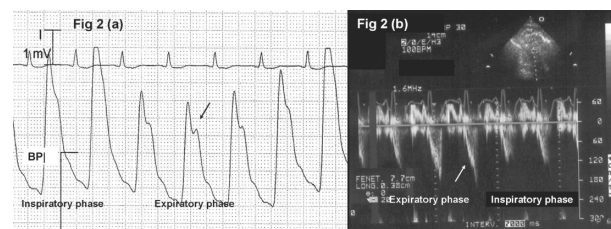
A, Blood pressure (BP): persistence of bisferiens arterial pulse (arrow), pulse pressure variation, 25%. B, Continuous wave Doppler analysis of the subaortic flow: subaortic flow acceleration (arrow), during the expiratory phase.
